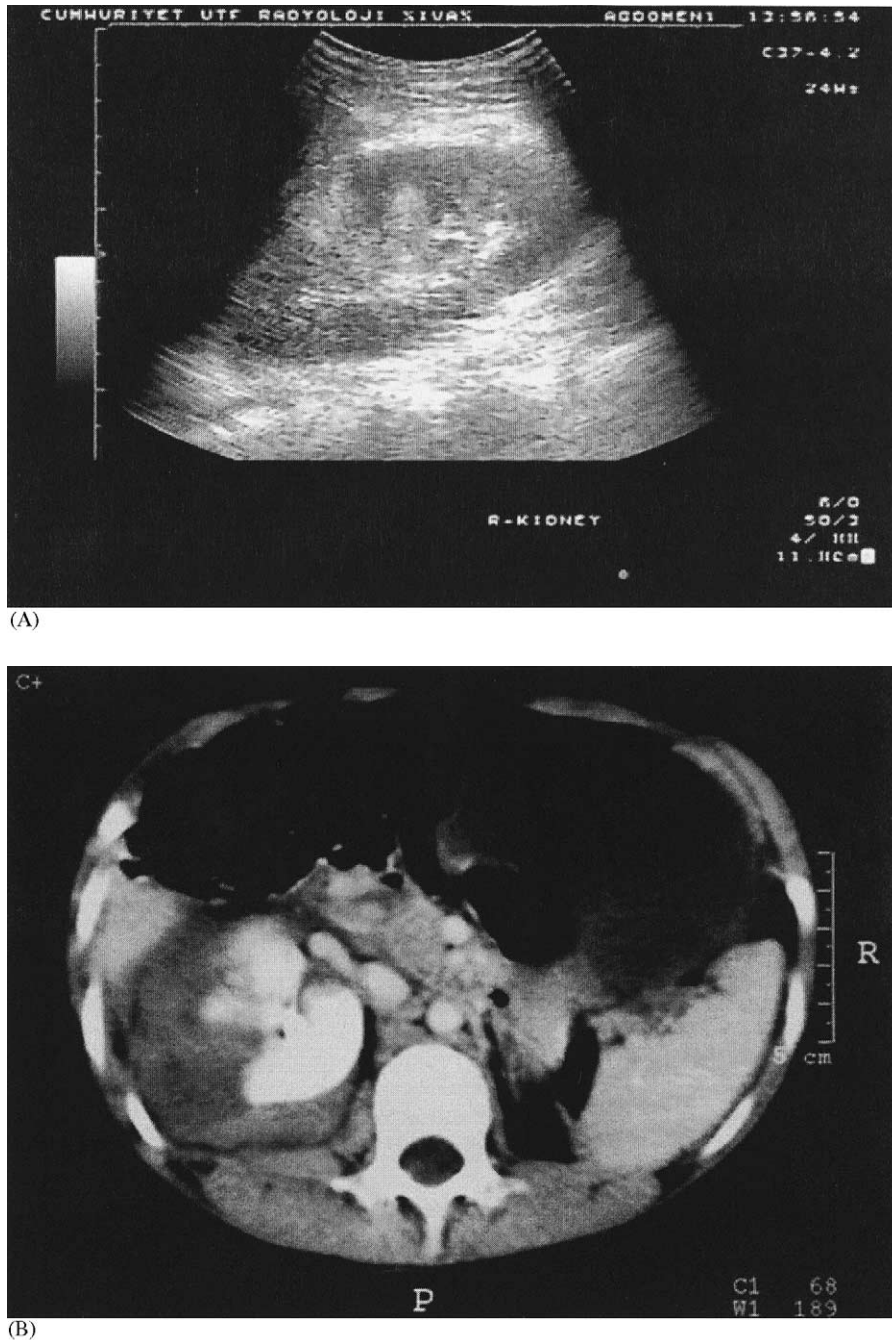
(A) Transverse sonogram shows perinephric hematoma and absence of normal renal echogenicity. (B) Post contrast CT scan of the same case reveals a perinephric hematoma and laceration of the right kidney.
